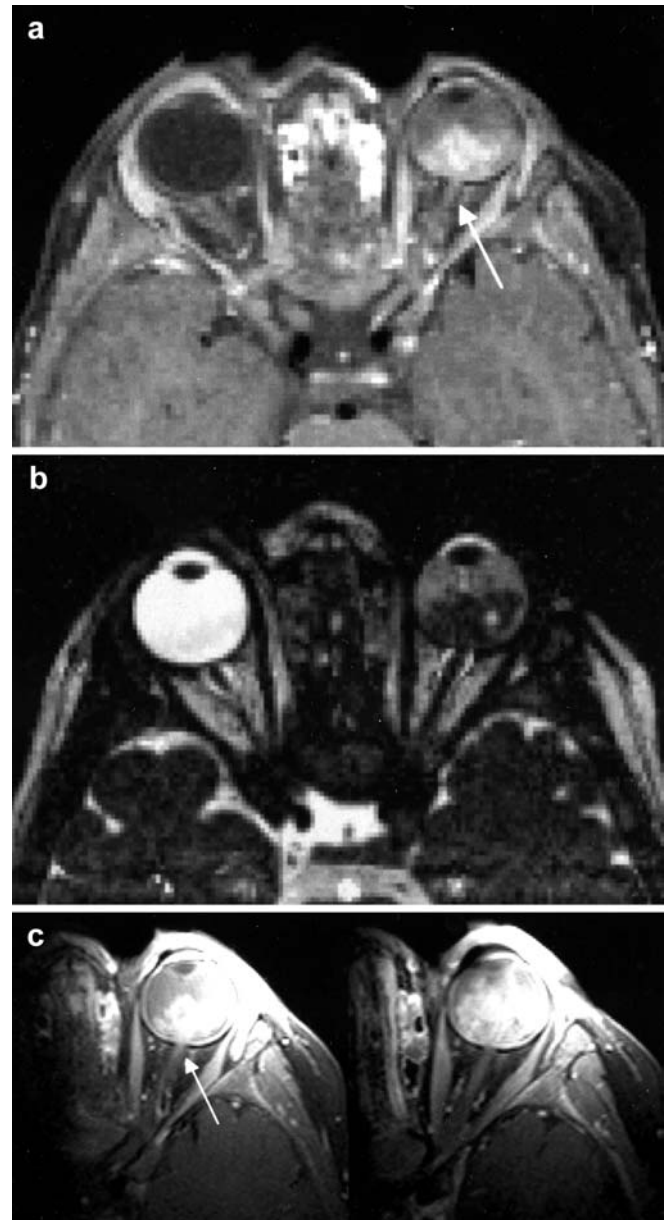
A 21-month-old boy with retinoblastoma infiltration of the optic nerve on the left eye. a High-resolution T1-weighted fat sat sequences after Gadolinium application in transversal and parasagittal slices. b Transversal reconstructed CISS images did not reveal optic nerve infiltration in this case. c High-resolution contrast-enhanced T1-weighted transversal images with fat sat using the surface coil placed over the left eye with higher image resolution
